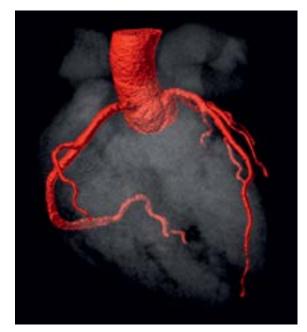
3D reconstruction of a cardiac CT scan showing the anatomy of the coronary arteries.
